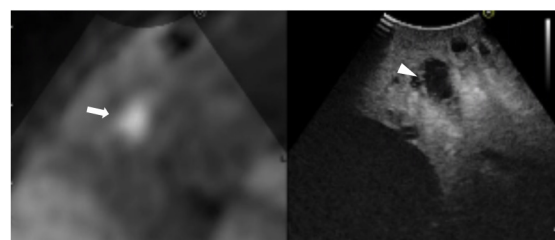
Still intraoperative real-time virtual sonography image in Case 2. Preoperative diffusion-weighted magnetic resonance imaging (DW-MRI; left side) and CE-IOUS (right side) were synchronized. The CE-IOUS image demonstrated a hypoechoic nodule (arrowhead) at the same site where DW-MRI demonstrated a lesion that was strongly suspected of being a liver metastasis (arrow).
